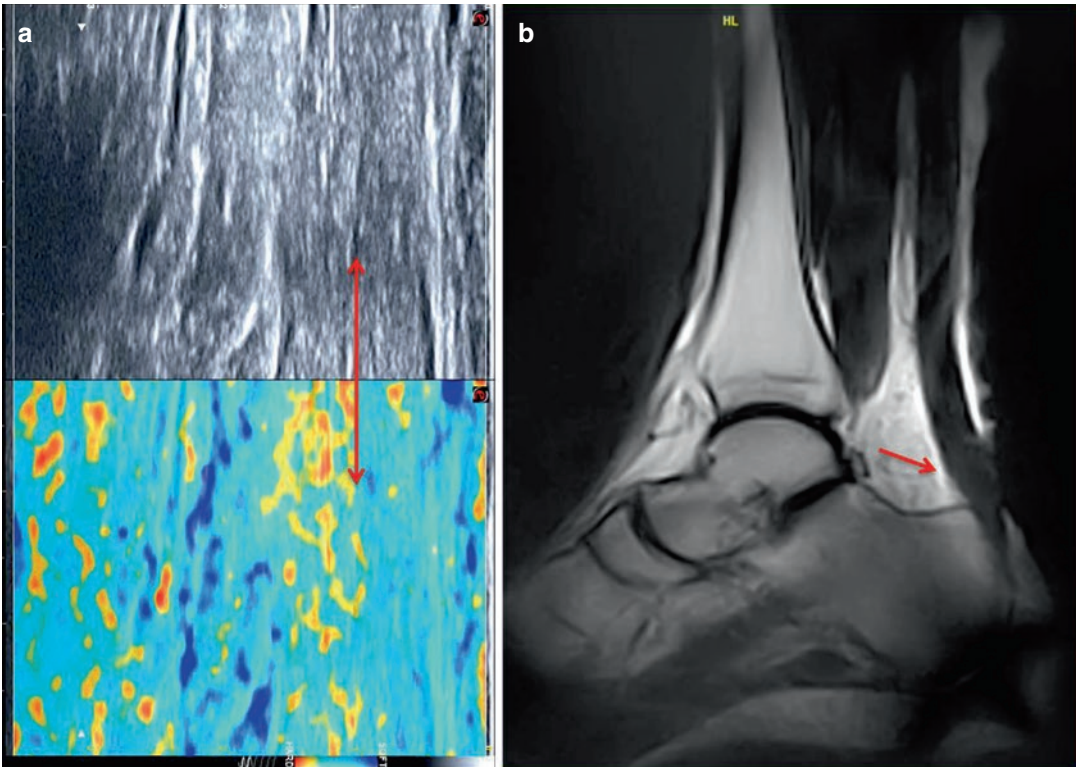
(a, b) Comparison of dynamic US, elastography and MRI scans demonstrating degeneration secondary to overload tendinopathy of the Achilles tendon
